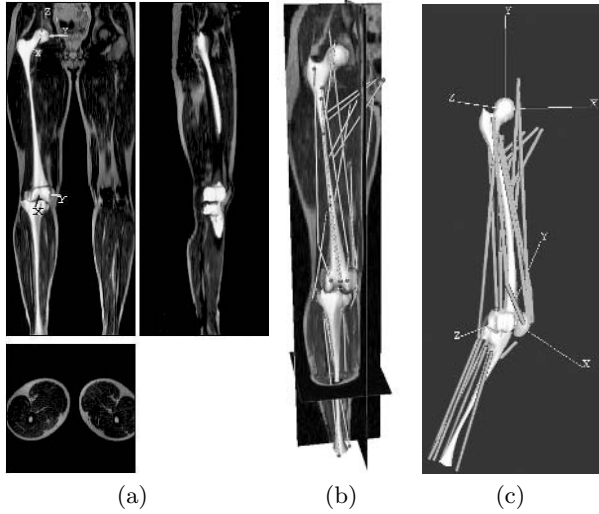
(a) Starting from T1 weighted SE MR images a subject-specific musculoskeletal model was built containing all necessary bone models and joint kinematics from the hip and knee joint. (b) Lines of action from 20 major muscles were integrated in the model. (c) Finally, the model was successfully imported in SIMM where it can be animated (notice the implied knee flexion) using the calculated biomechanics and used for biomechanical analysis.
